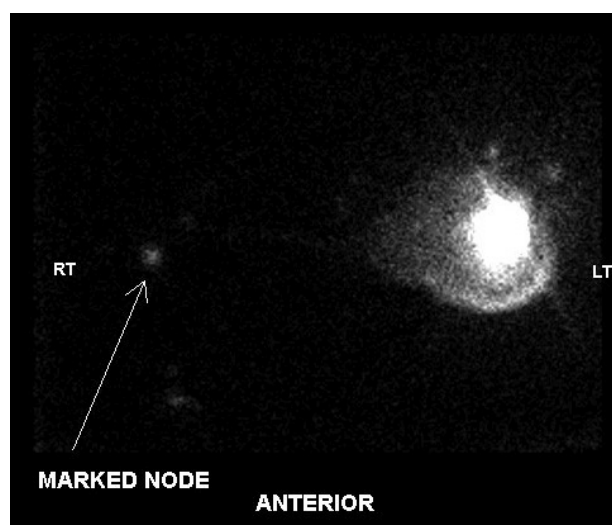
Lymphoscintigraphy showing right axilla sentinel lymph node radiotracer uptake following administration of technetium^{99m} in left breast. LT, Left; RT, Right.
